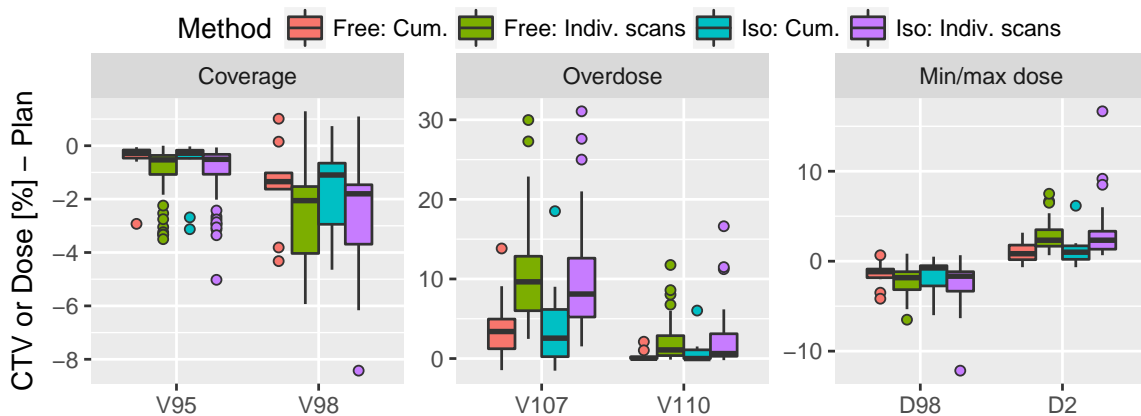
Distribution of the difference between the adaptations and the original plans. The difference was taken patient by patient, either using the cumulative dose distribution or using the dose distributions on the individual scans. Both adaptation modes here included behaved similarly. Target coverage was well maintained in the cumulative distribution. The distributions on the individual CBCTs presented bigger fluctuations.
